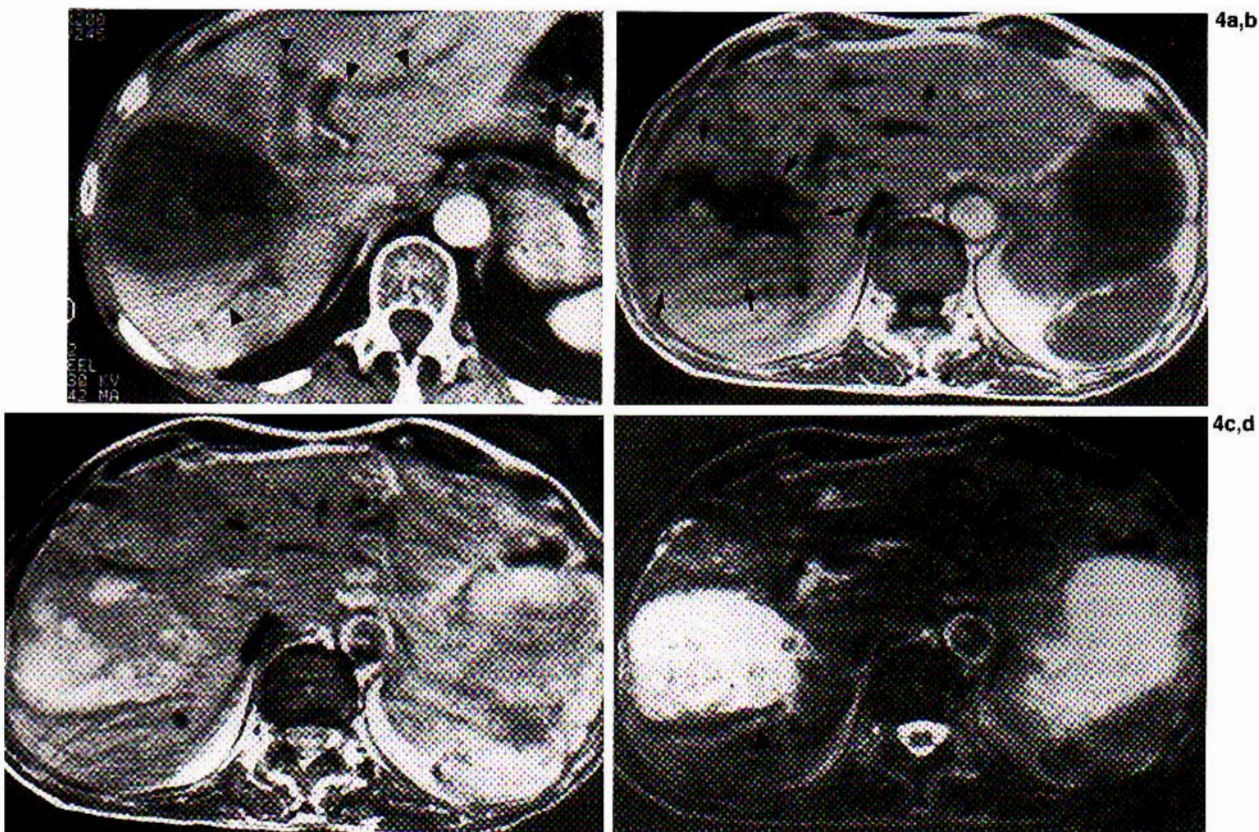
Right necrotic mass involving the hilum. a: Postiodine CT scan shows large necrotic mass with biliary dilatation (arrowheads). b: T1-weighted MR image (TR 500 ms) shows central necrosis as an area of very low signal, surrounded by an irregular rim of low signal due to fibrous and parasitic tissue (arrows). c and d: T2-weighted images [TR 2,000 ms; TE 50 ms (c) and TE 150 ms (d)] show the peripheral fibrous and parasitic tissue to have a higher signal than the necrosis on the first echo (c) and a lower signal on the third echo (d). The biliary dilatation is visible on the third echo (arrowheads, d), but CT is more accurate.
